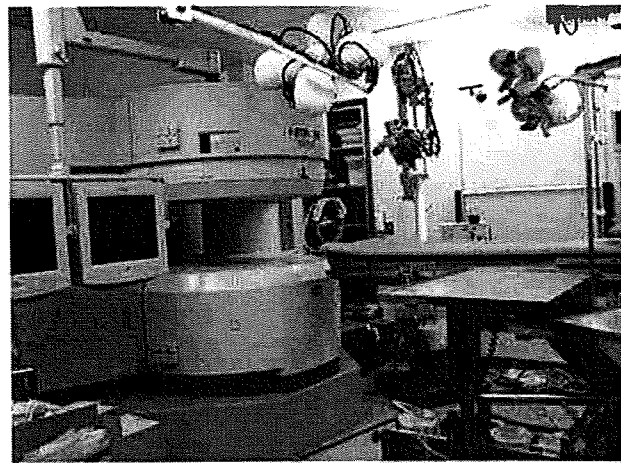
General view of the intelligent operating theater in the Tokyo Women's Medical University with the hamburger-like open intraoperative MRI scanner (AIRIS II™, Hitachi Medical Co., Chiba, Japan).
